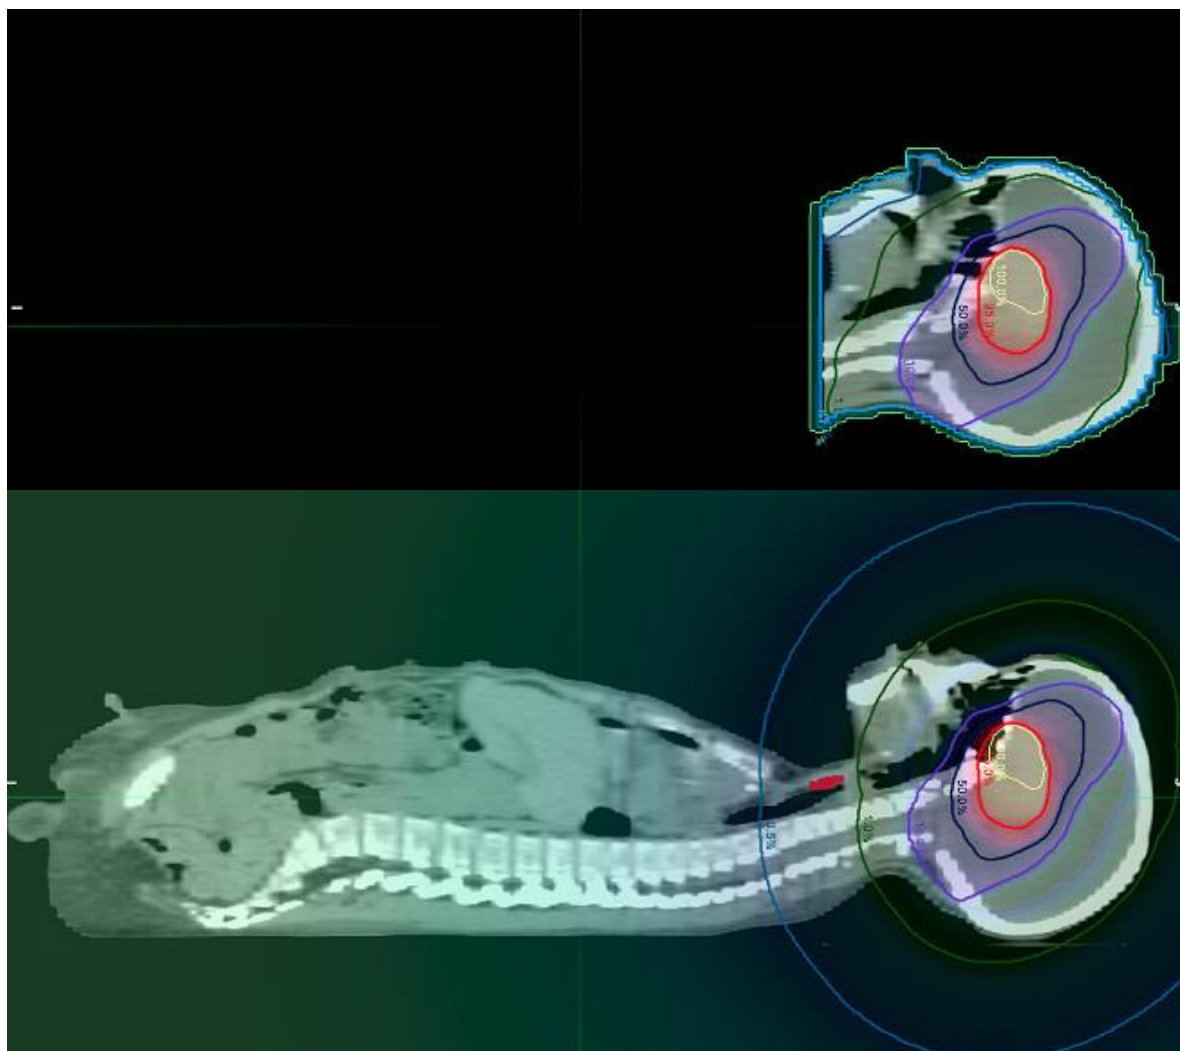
Shown are the sagittal views of the dose distribution from the primary fields of the 8-year-old boy on the original CT image set (upper), and the dose distribution from in-field (TPS) and out-of-field (model) components on the fused secondary CT image set (lower). The displayed isodose lines are 100% (yellow), 95% (red), 50% (black), 10% (purple), 1% (green), 0.5% (blue), and 0.1% (bright green). The location of the thyroid in the secondary image set is contoured in red (lower).
